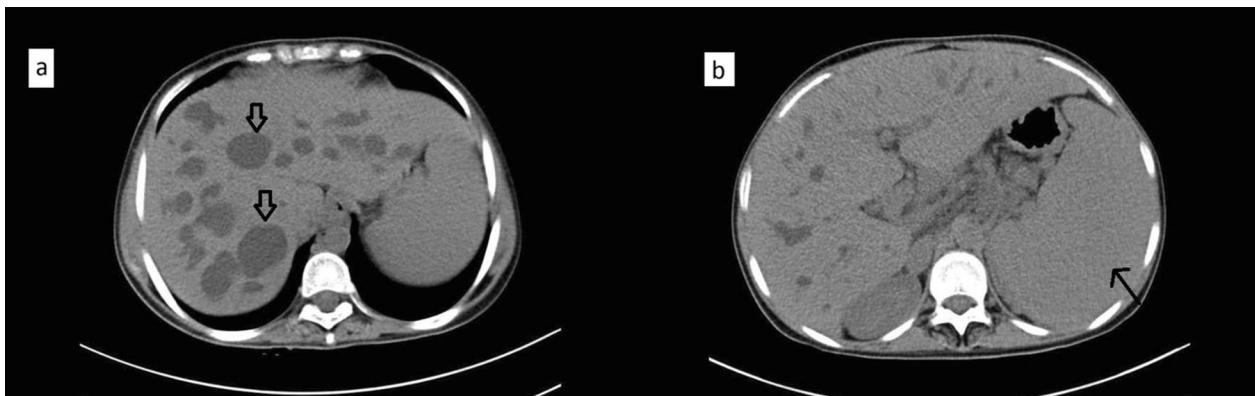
a Axial contrast-enhanced computed tomography scan of the abdomen, demonstrating multiple intrahepatic cystic lesions (black arrows), representing saccular dilatation of the intrahepatic bile ducts, characteristic of Caroli's disease. b Axial contrast-enhanced computed tomography scan showing a larger saccular dilatation (black arrow) in the liver, along with hepatomegaly (enlarged liver) and splenomegaly (enlarged spleen)
